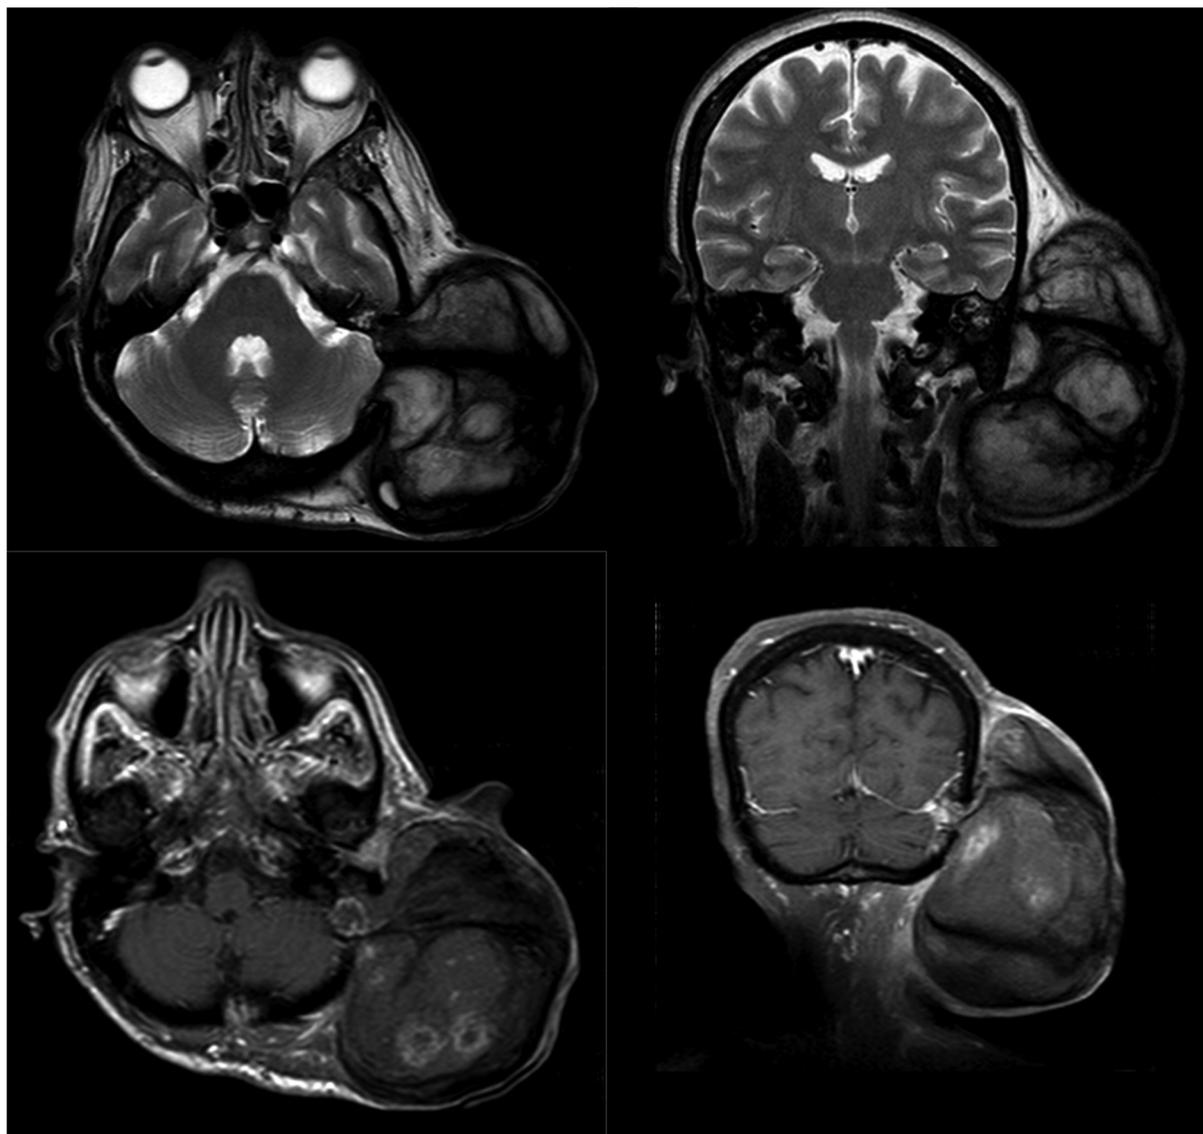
Magnetic resonance imaging demonstrating a heterogenous but predominantly hypointense signal on T2 images with small areas of enhancement after gadolinium infusion.
